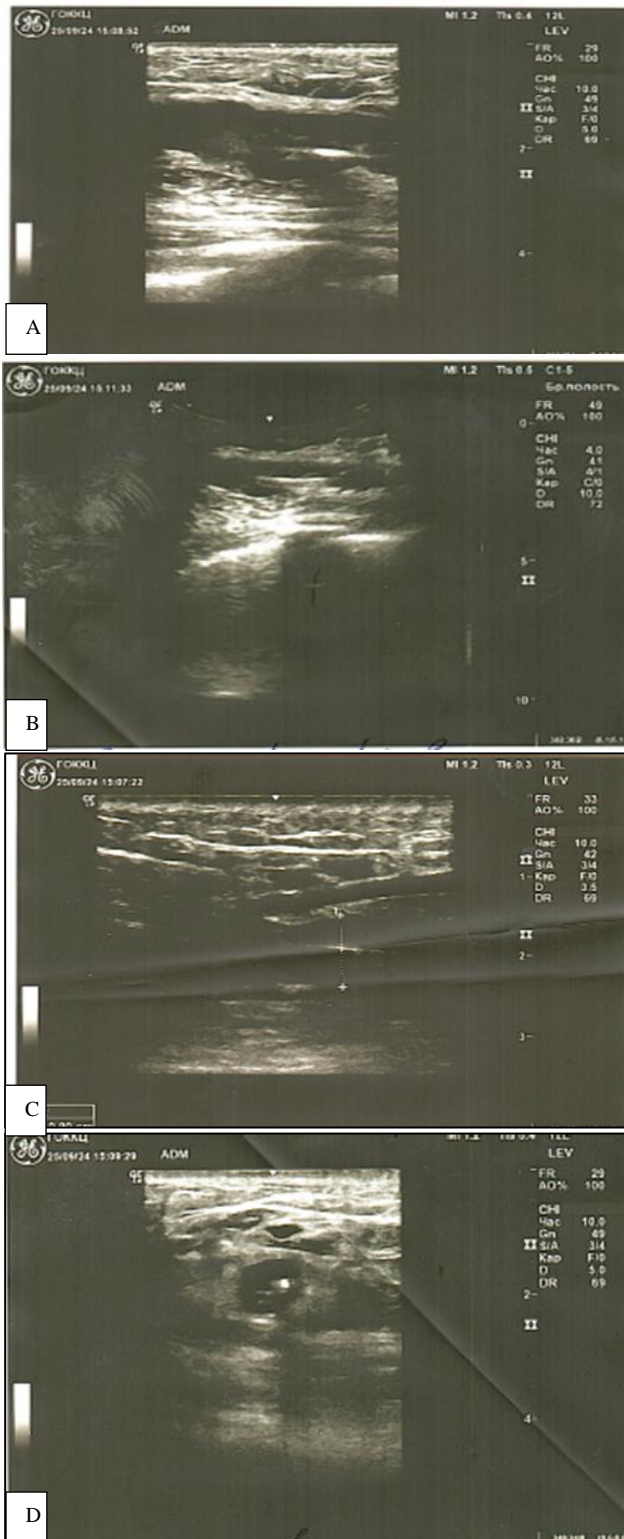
(A-D): Ultrasound of the pacemaker bed and electrode channel. Ultrasound of the pacemaker bed (linear sensor). Ultrasound of the pacemaker bed (convex sensor) on the left in the subclavian region, in the projection of the pacemaker bed subcutaneously, a fluid formation 47×14 mm in size is located. Ultrasound of pacemaker electrode in longitudinal position and ultrasound of pacemaker electrode in transverse position.
